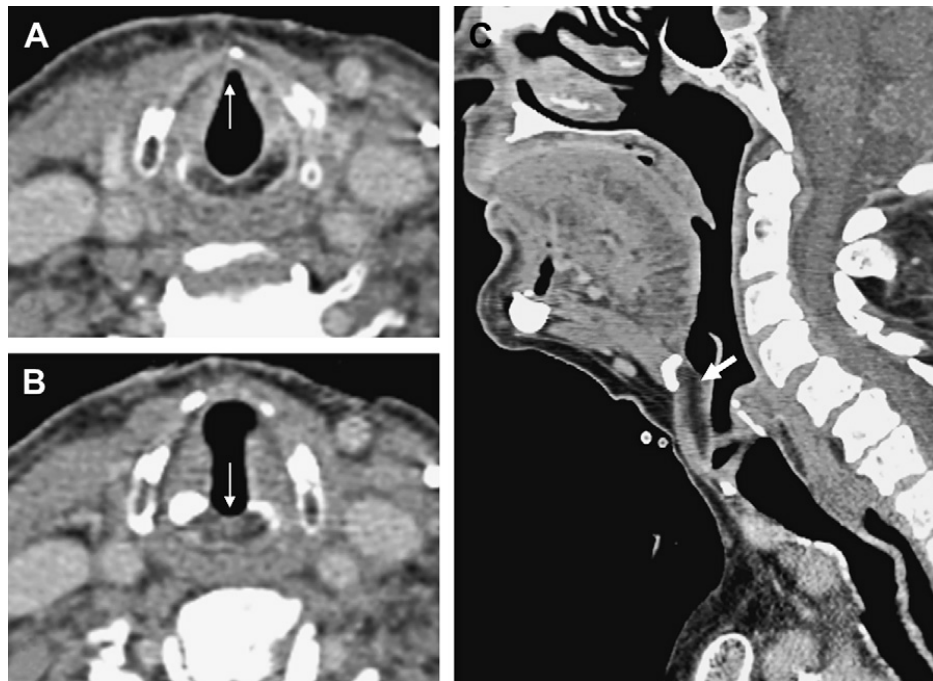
Axial CT image through the glottis.
